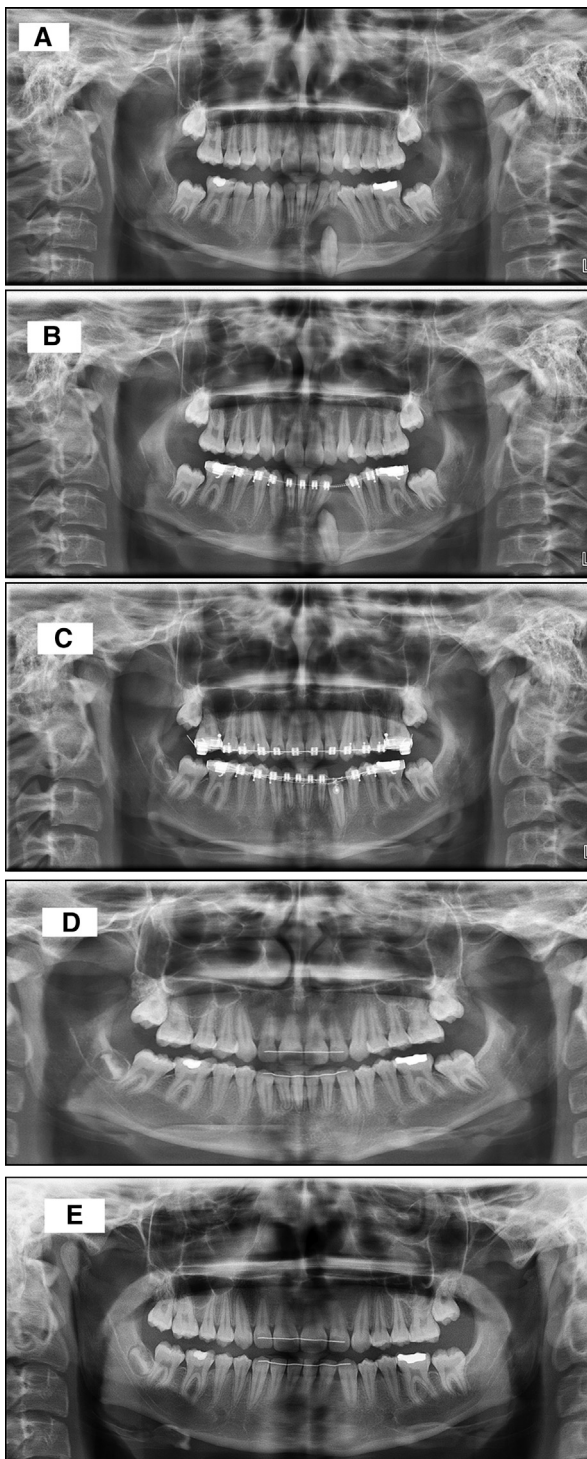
Panoramic radiographs: A, pretreatment; B, after surgery; C, 6 months after orthodontic button was bonded; D, posttreatment; E, 3 years after the surgery.
